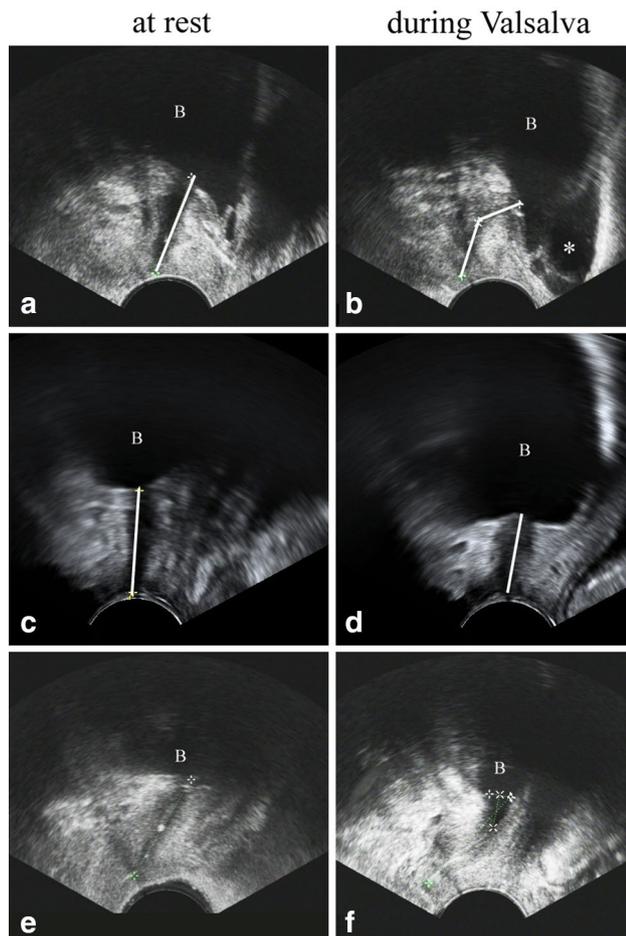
Images gained from introital ultrasound in three different women. Image quality varies due to default settings the US investigator used for documentation (a, b) presentation of RBD and a cystocele (*). (c, d) Presentation of VBD. (e, f) Presentation of urethral funneling. *B* bladder
